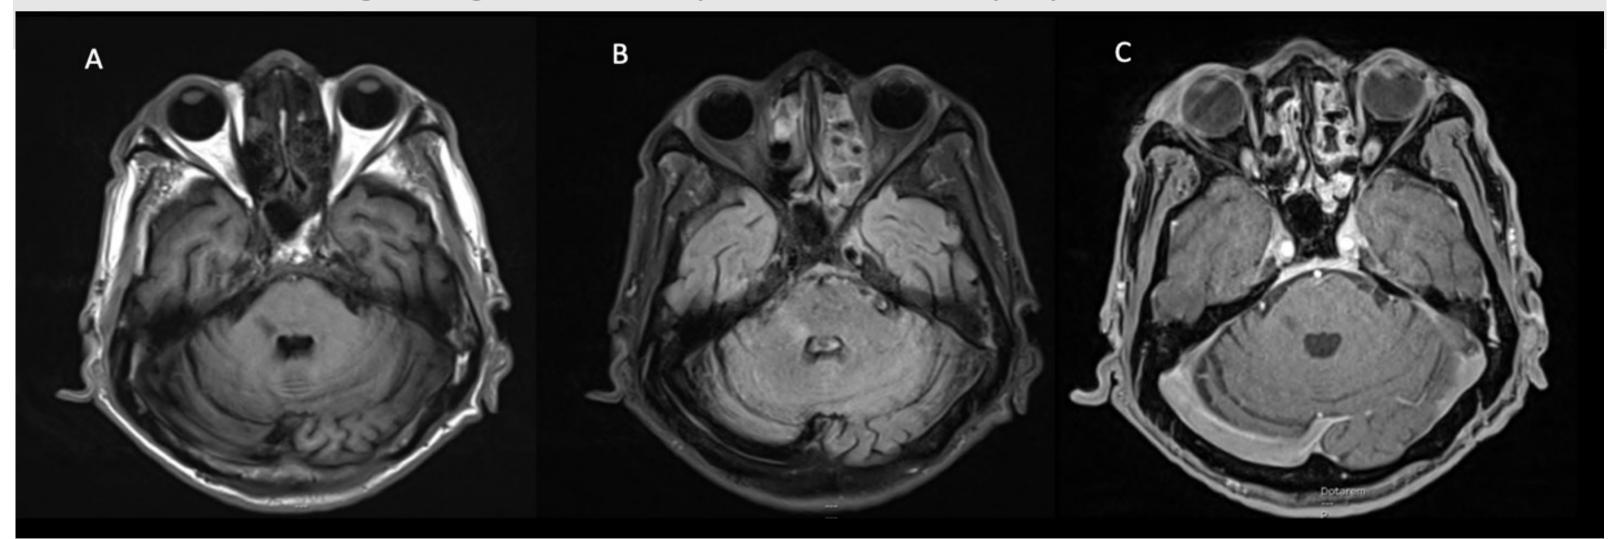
shows magnetic resonance imaging of the brain in the first case report, demonstrating a hypointense lesion on T1W imaging and a hyperintense lesion on T2W FLAIR imaging at the right lateral aspect of the pons and right cerebellar peduncle involving the course of the fascicular segment of the right trigeminal nerve (A, B) without gadolinium enhancement at the lesion (C).
